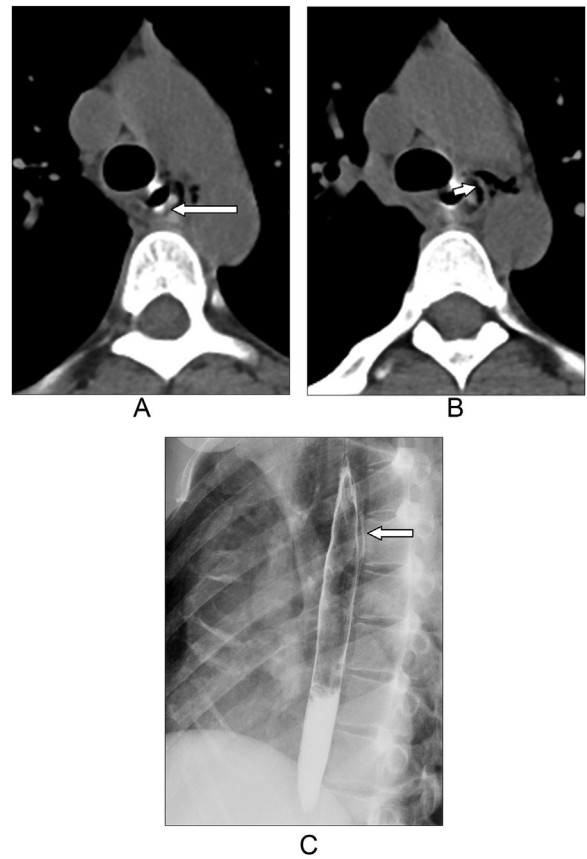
Thirty-nine year-old woman with a history of EoE and with recurrent dysphagia. (A,B) Axial CT with oral contrast images show outpouching of oral contrast in the mid left lateral esophageal wall (big arrow; A) and associated pneumomediastinum (small arrow; B), suggestive of focus of extravasation. Note the esophageal wall thickening. (C) Esophagram image shows contrast leak was identified within the esophageal wall in the thoracic esophagus (arrow), suggestive of an intramural esophageal dissection.
